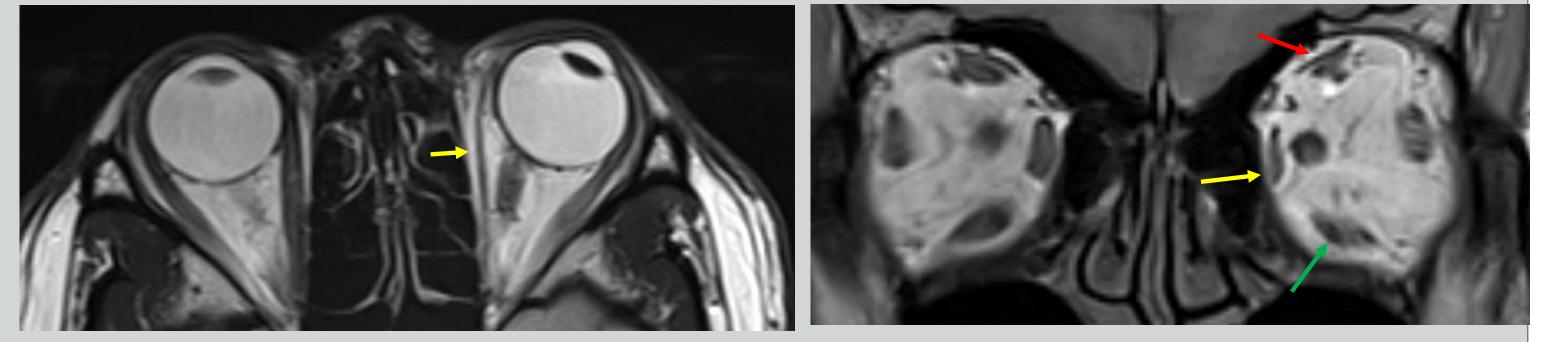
MRI of patient with left partial 3rd nerve palsy shows thin 'shoestring' left medial rectus (yellow arrows) and reduced muscle volume of left superior rectus (red arrow) with relatively preserved left inferior rectus volume (green arrow).
